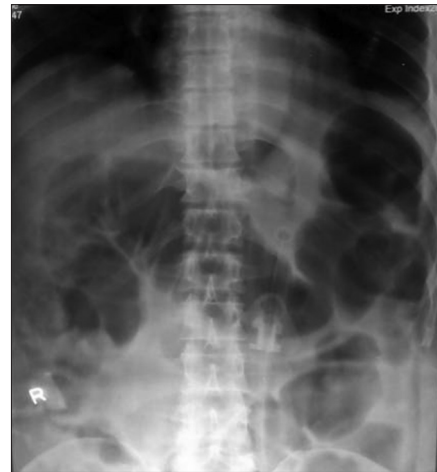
Abdomen roentgenogram taken on the day of distension post percutaneous endoscopic gastrostomy
